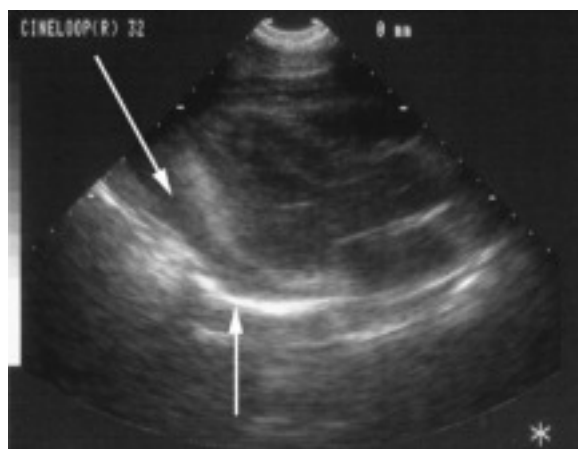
Parasternal long-axis view of a pericardial effusion from a stab wound to the heart. Upper arrow points to hypoechoic effusion and lower arrow points to the hyperechoic posterior pericardium.
